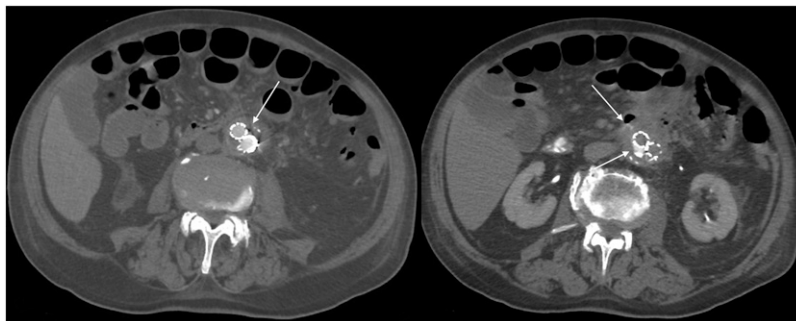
Left. CT scan with endovenous contrast: no visible signs of endoleak. The arrow indicates bubbles in the aortic aneurysm sac. Right. CT scan with oral contrast. The arrows indicate contrast in the aortic aneurysm sac.
